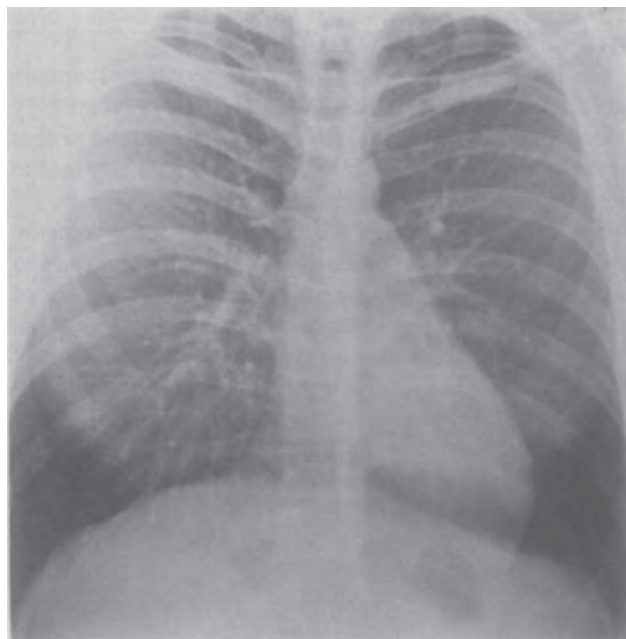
Chest X-ray demonstrating displacement of the cardiac silhouette to the left and flattened upper left cardiac border. *Source:* Van Son *et al.* 1993 [5]. Reproduced with permission of Elsevier.
